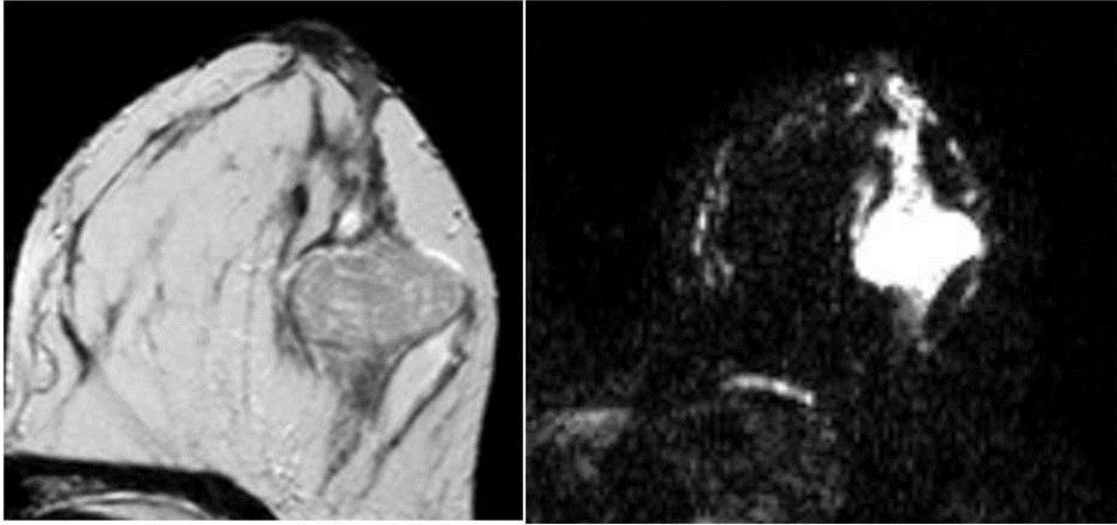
13. T2 WI and DWI show a Myxoid Fibroadenoma
